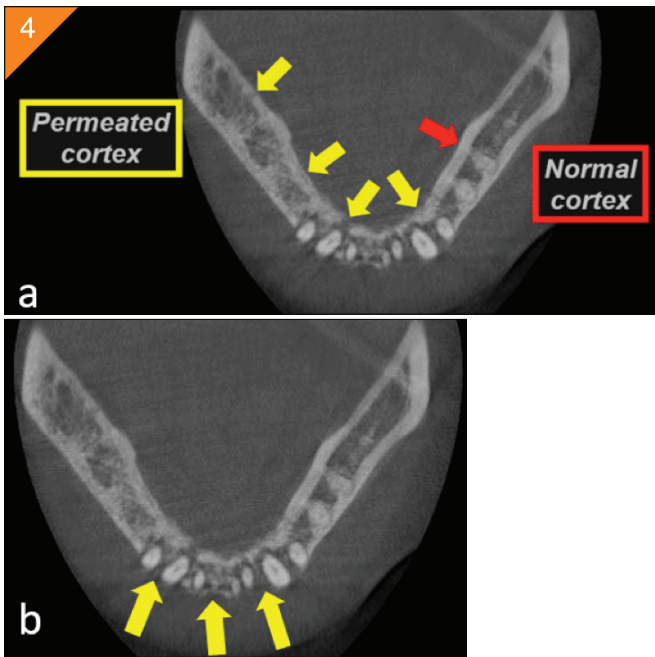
a) Axial view of CBCT mandibular lingual cortex exhibits multiple low density areas (permeative changes) in cortical bone associated with metastatic breast carcinoma. b) Axial view of CBCT mandibular labial/buccal cortex exhibits multiple low density areas of permeative changes associated with metastatic breast carcinoma.
